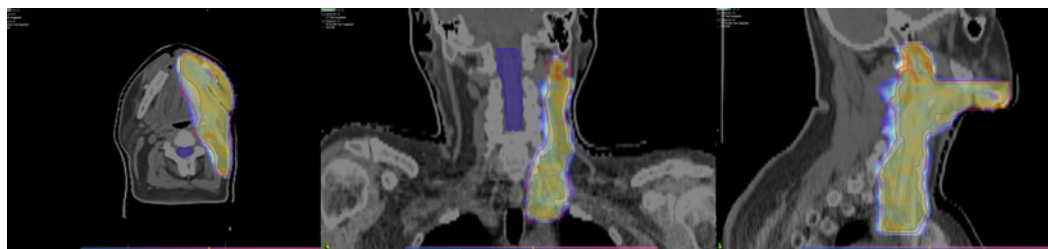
Conventional RT. Dose distribution is shown on the CT scan.
